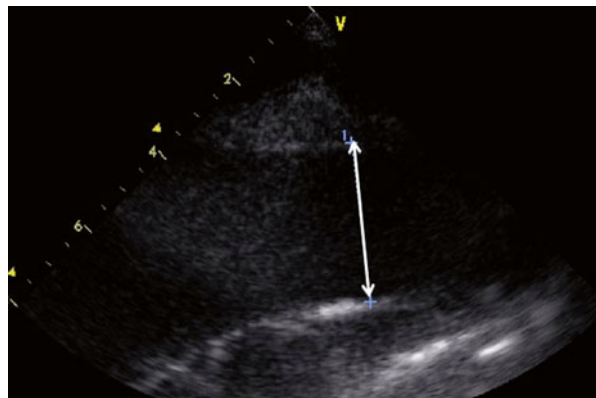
Imaging of the ascending thoracic aorta obtained after moving the transducer one intercostal space toward the head from the standard parasternal long-axis view
